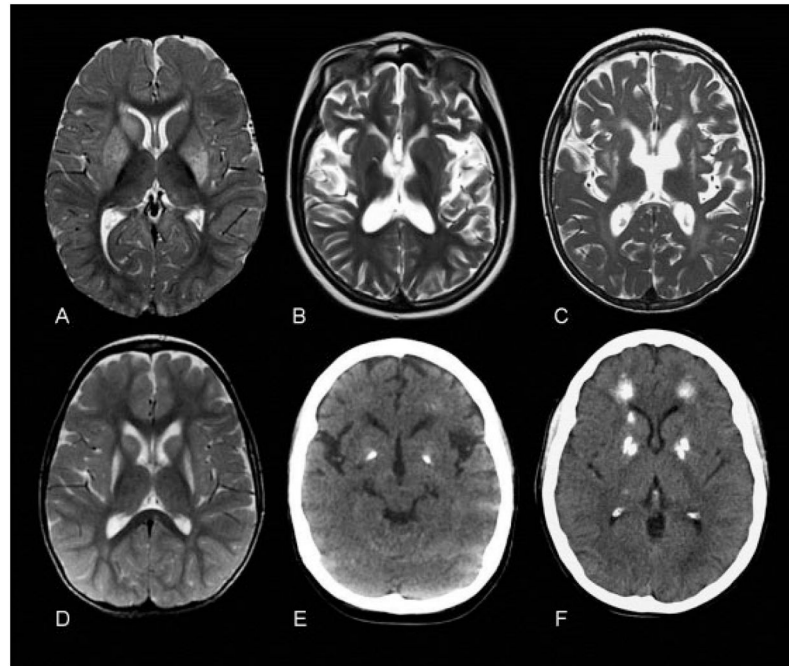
Characteristic neuro-radiological features of ADAR1-related disease. Images (A) and (D) are axial T2 images of AGS251, presenting at 9 months of age with bilateral striatal necrosis following varicella zoster infection, showing characteristic high signal and swelling of head of caudate and putamen (A). (D) Follow-up at 35 months shows persisting signal change and shrinkage of caudate and putamen. Images (B) and (E) are from AGS150, a 10-year-old child presenting with an Aicardi–Goutières syndrome phenotype. (B) T2 axial MR shows cerebral atrophy with mildly increased signal in white matter. (E) CT shows dense bilateral globus pallidus calcification. Image (C) is of a patient presenting with an Aicardi–Goutières syndrome phenotype (AGS810_P1). (C) T2 axial MR at 5 years shows marked cerebral atrophy, white matter high signal, and signal change and shrinkage of the putamen. (F) CT scan of his mother (AGS810_P2) aged 34 years shows dense calcification of globus pallidus, head of caudate, and deep frontal white matter. Her MR (not shown) was normal. CT, computed tomography; MR, magnetic resonance.
